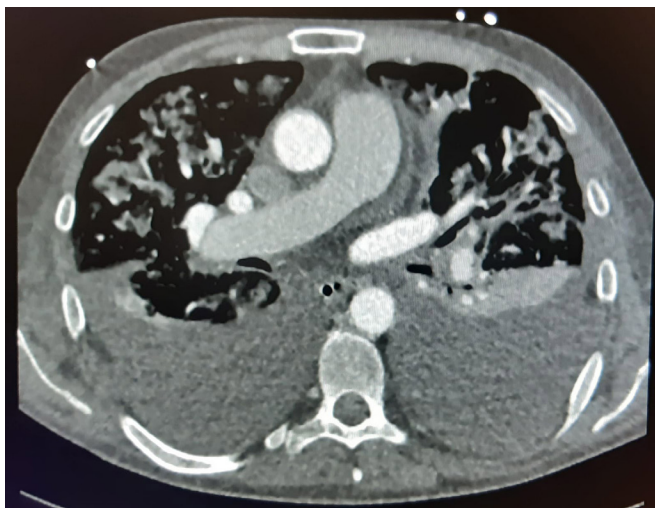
Lung CT scan with massive bilateral pleural effusions, showing no signs of pulmonary embolism and no signs of severe COVID-19 pneumonia.
